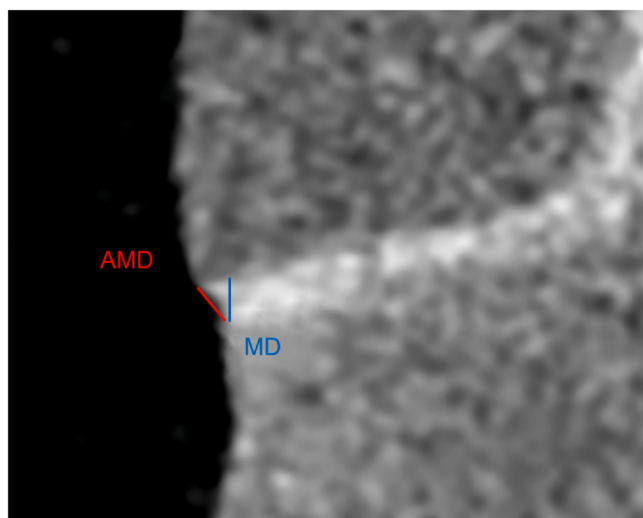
Microcomputed tomography scan image (magnified at margin area): measurement of marginal discrepancy (MD) (perpendicular distance between internal margin of indirect partial restoration and preparation margin on tooth, and absolute marginal discrepancy (AMD)(distance between restoration and tooth preparation margins).
